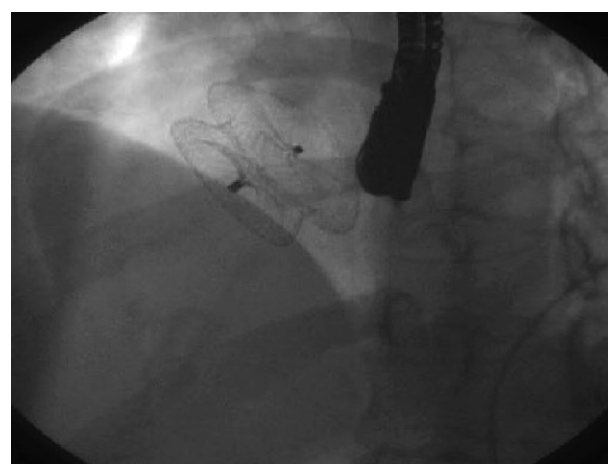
Fluoroscopy image showing Amplatzer Septal Occluder in position (the transoesophageal probe is seen over the spine).
